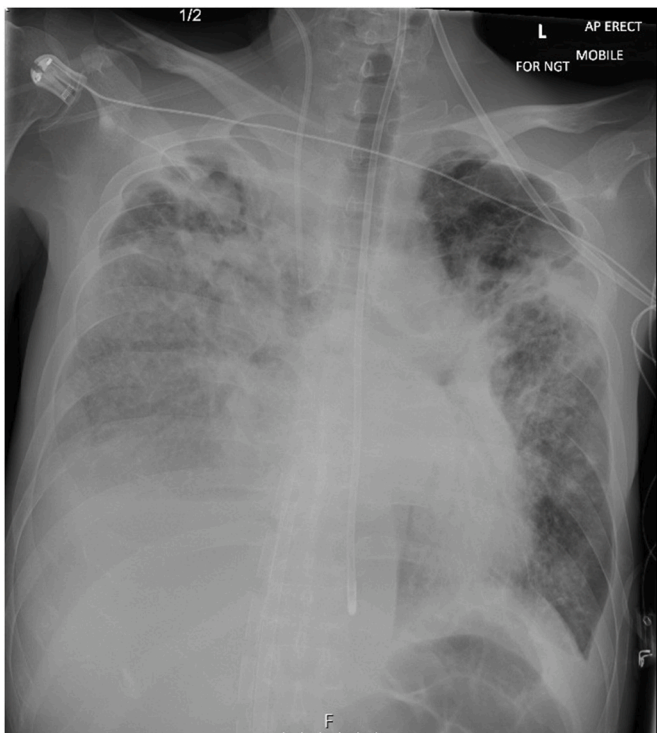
Chest X-ray before intercostal chest drain insertion.
